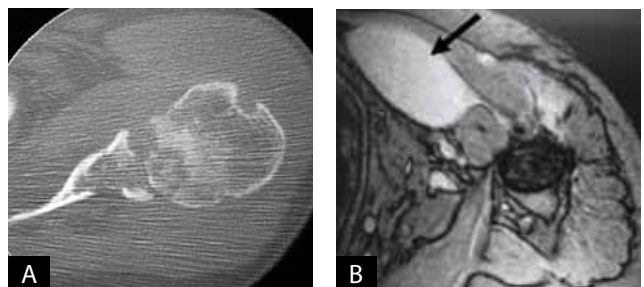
Case 1 imaging. (A) Preoperative computed tomography shows multiple erosive lesions with segmental necrotic bones in humeral head and severely destroyed glenoid. (B) Preoperative magnetic resonance imaging shows large cyst with effusion beneath pectoralis major (arrow). (C) Ten-year follow-up radiograph shows deformed humeral head and glenoid with sclerotic margin.
